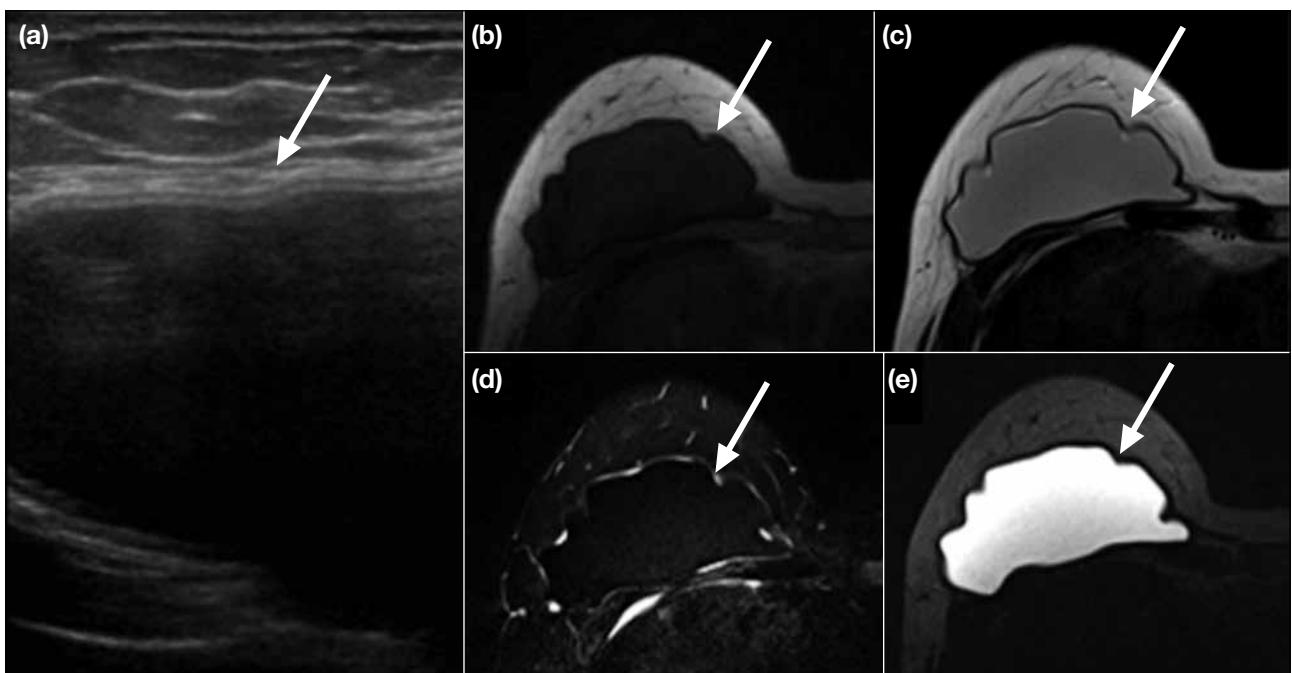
A 38-year-old woman with a history of single lumen silicone implant (arrows). (a) Ultrasound image shows intact implant. Subsequent magnetic resonance imaging (MRI) is performed to ascertain the implant integrity. (b) T1-weighted MRI scan, (c) T2-weighted (T2W) turbo spin echo MRI scan, (d) T2W MRI scan with fat and silicone saturation, and (e) T2W MRI scan with fat and water suppression. Intact silicone implant showing T2W hyperintense signal that is suppressed on silicone suppression image and not on water suppression image (e).
